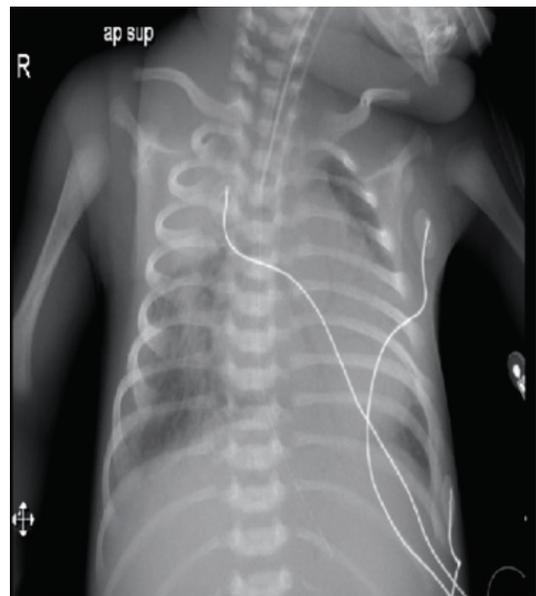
Chest X-ray shows diffuse infiltrations on the right side
